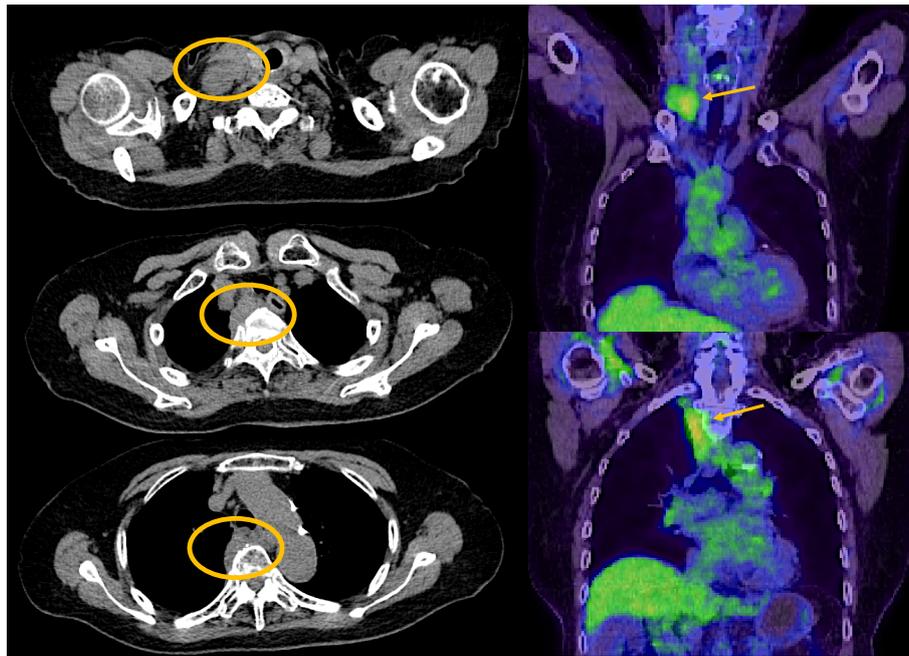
FDG-PET/CT imaging. Lymphadenopathy in the right supraclavicular fossa and a paraspinal lesion of the thoracic spine were observed (circled). Abnormal accumulation of FDG was observed at SUVmax 4.0, in accordance with swollen lymph nodes and the mediastinum (arrow). Abbreviation: FDG-PET/CT (fluorodeoxyglucose-positron emission tomography/computed tomography)
